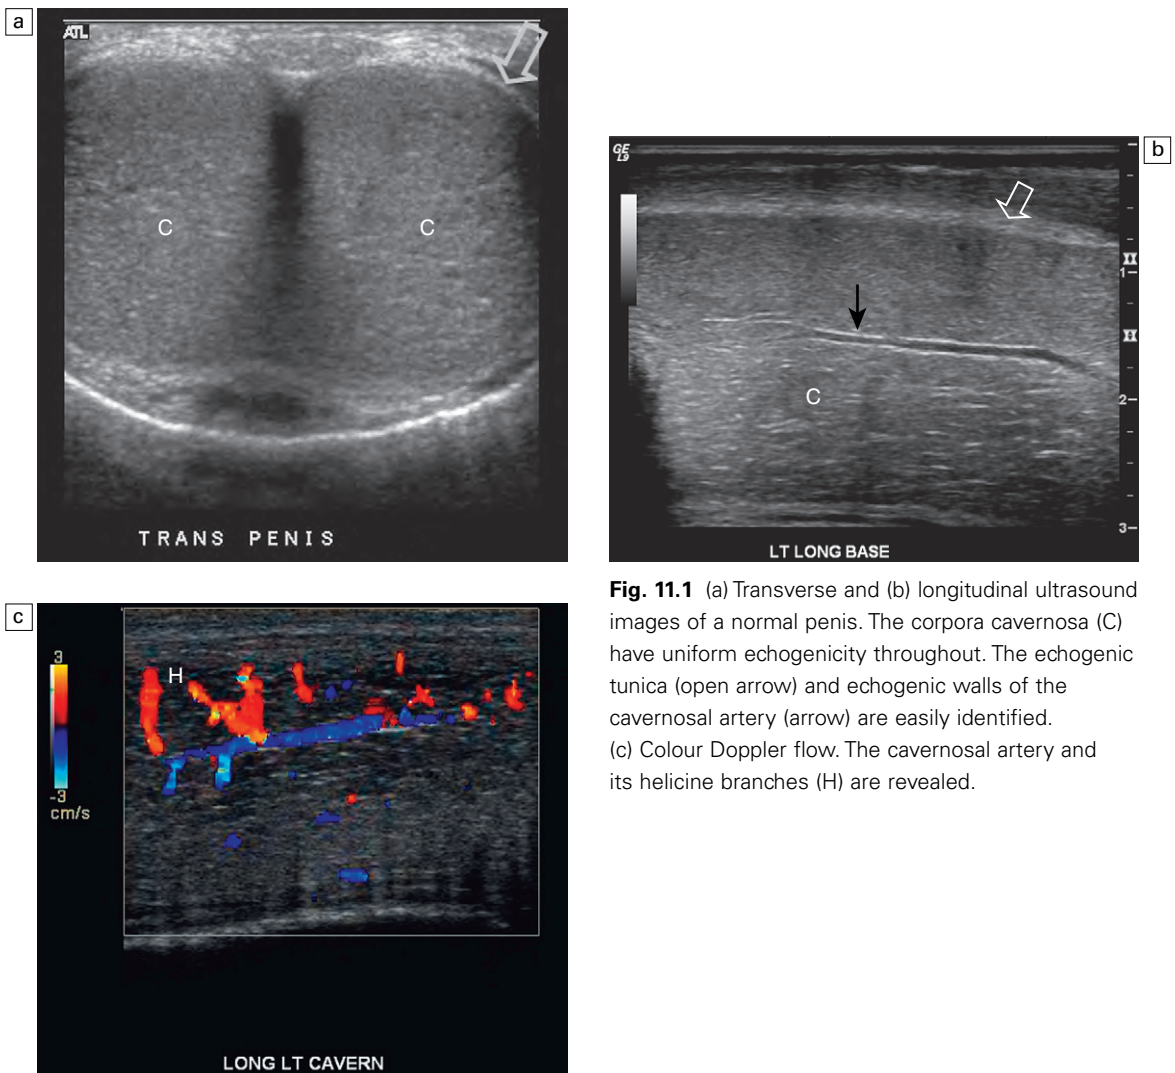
(a) Transverse and (b) longitudinal ultrasound images of a normal penis. The corpora cavernosa (C) have uniform echogenicity throughout. The echogenic tunica (open arrow) and echogenic walls of the cavernosal artery (arrow) are easily identified. (c) Colour Doppler flow. The cavernosal artery and its helicine branches (H) are revealed.
